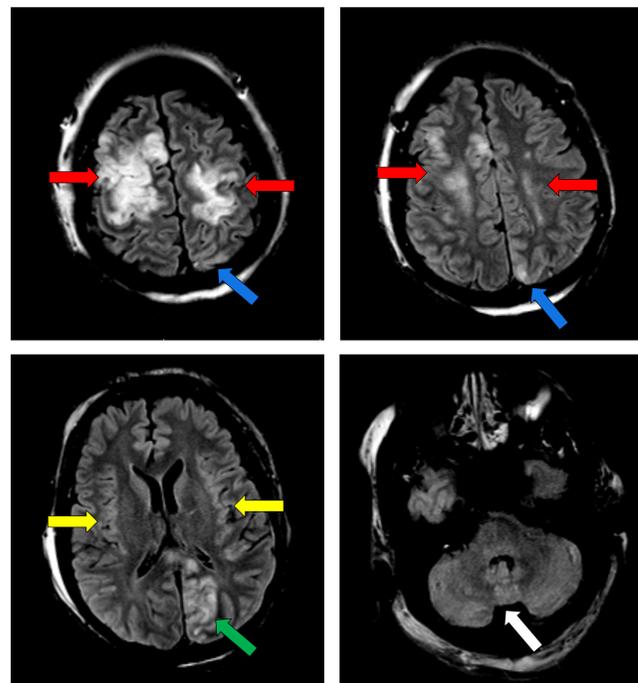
MRI Brain Axial FLAIR images demonstrating bifrontal (red arrows), biparietal (blue arrows), bitemporal (yellow arrows), left occipital (green arrow), and right dentate nucleus (white arrow) ischemia.
